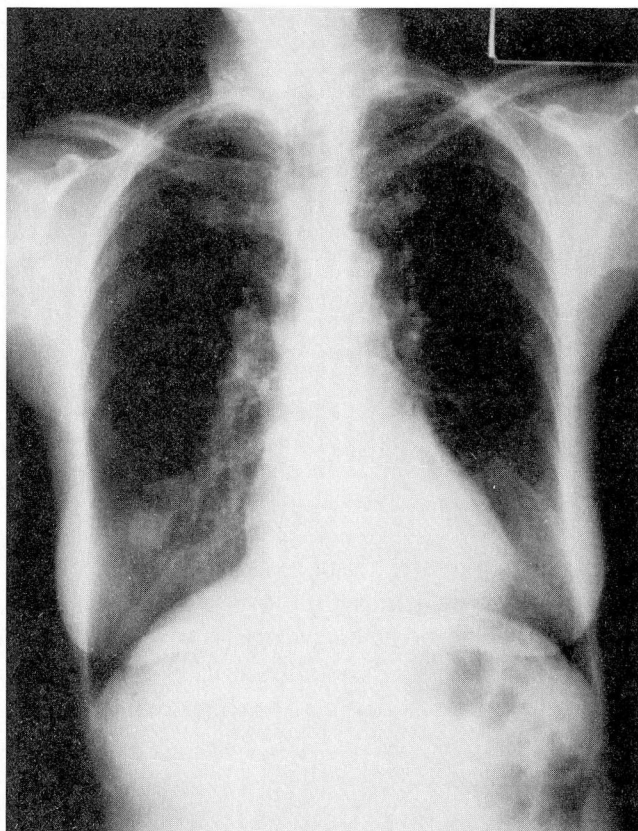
Chest radiograph demonstrating a solitary coin lesion in the lower lobe of the right lung.
